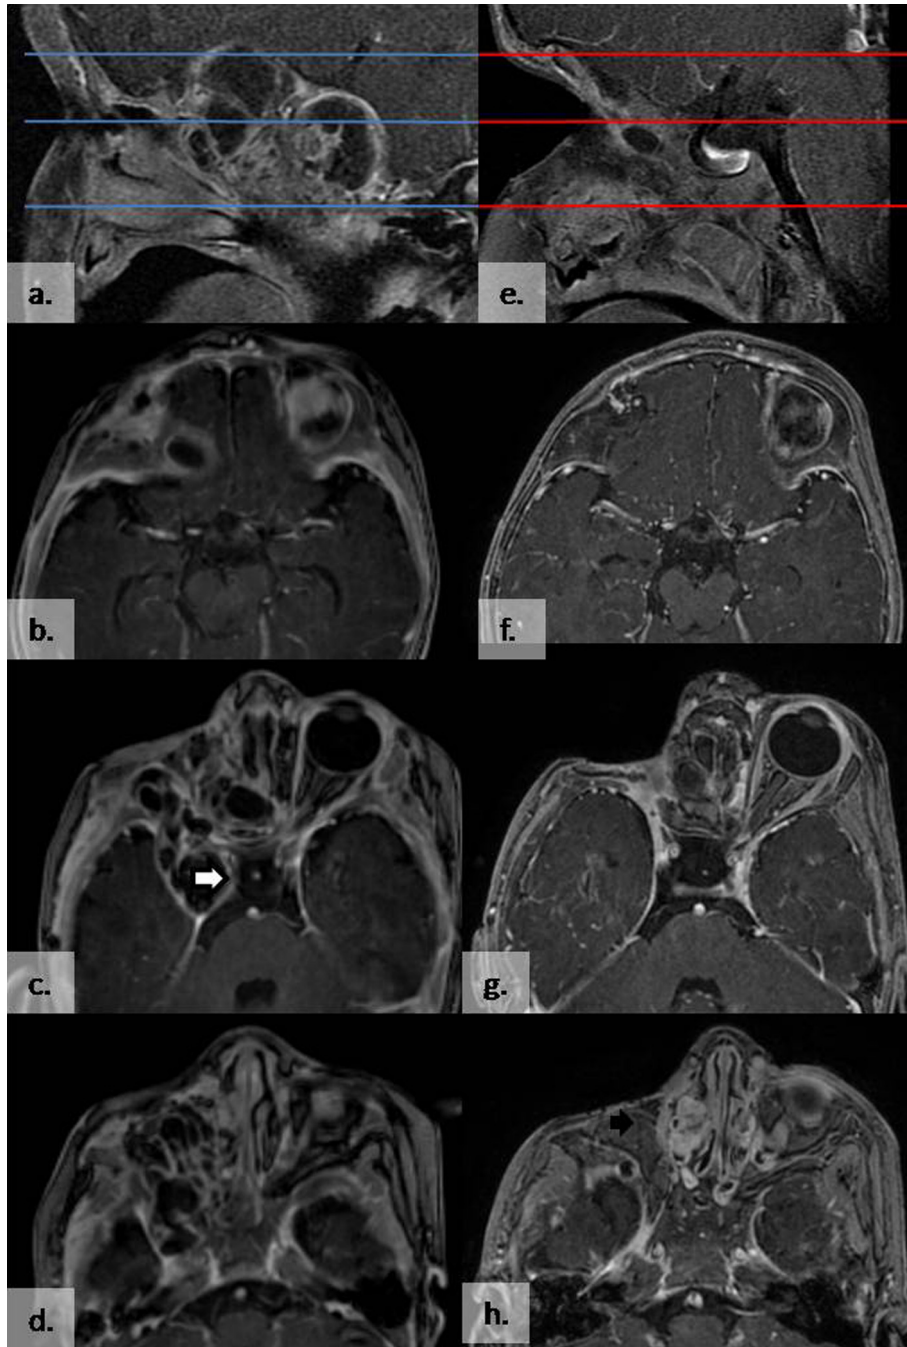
Magnetic Resonance Imaging Sagittal and axial cuts depicting extent of disease at presentation (a–d) and after resection (e–h) at orbital roof, mid-orbital and orbital floor level (a and e). White arrow: Disease involving cavernous sinus. Black arrow: Fat graft filling the orbital defect.
